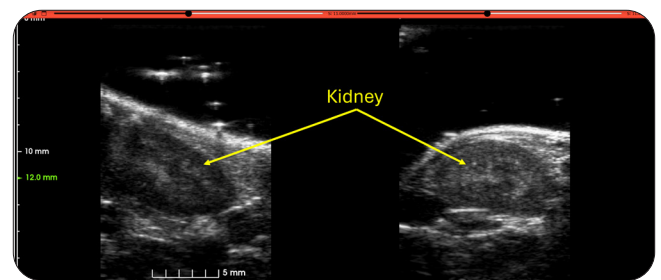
Ultrasound images of the kidney in the long-axis (left) and short-axis (right) views.
